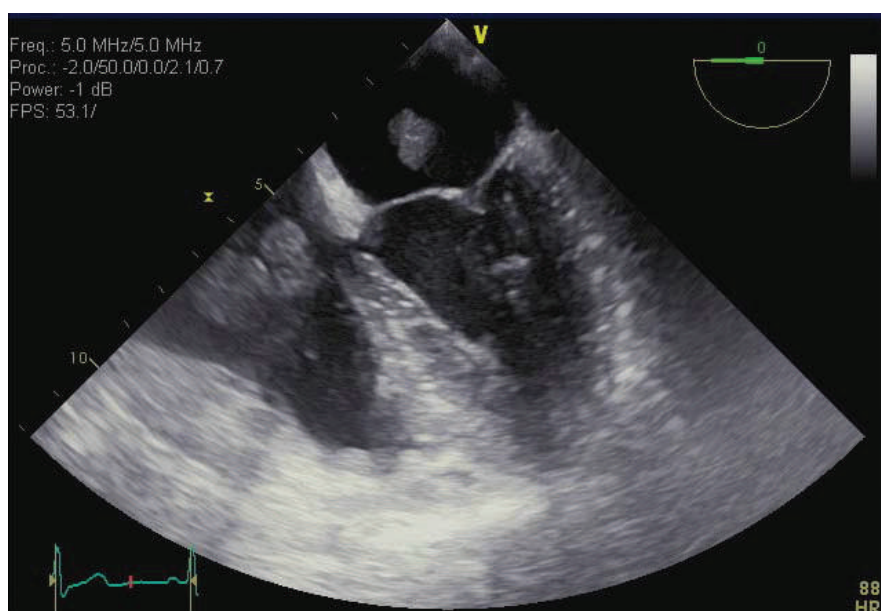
Transesophageal echocardiography four-chamber view, showing echodensity in the right atrium, left atrium, and left ventricle.
